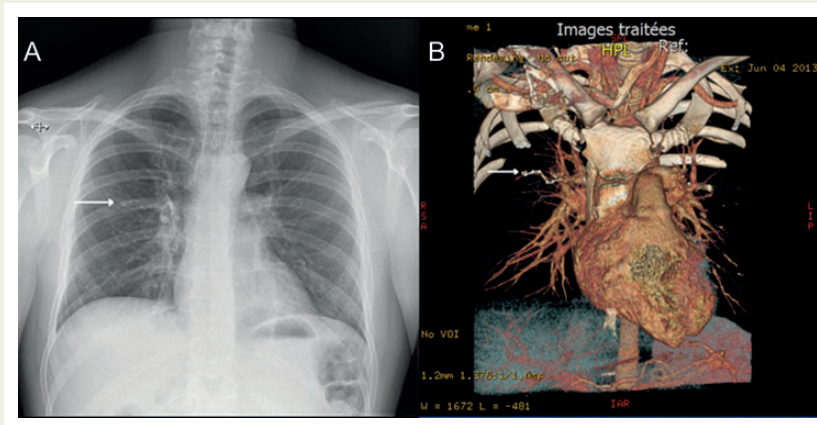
(A): Chest X-ray showing the location of the distal part of the ACHIEVE catheter in the posterior segment of the right superior pulmonary lobe (Arrow) (B): Chest computed tomography scan with three-dimensional reconstruction of the heart and the pulmonary vasculature; the ACHIEVE catheter is clearly visible in the segmental pulmonary vein (Arrow).
